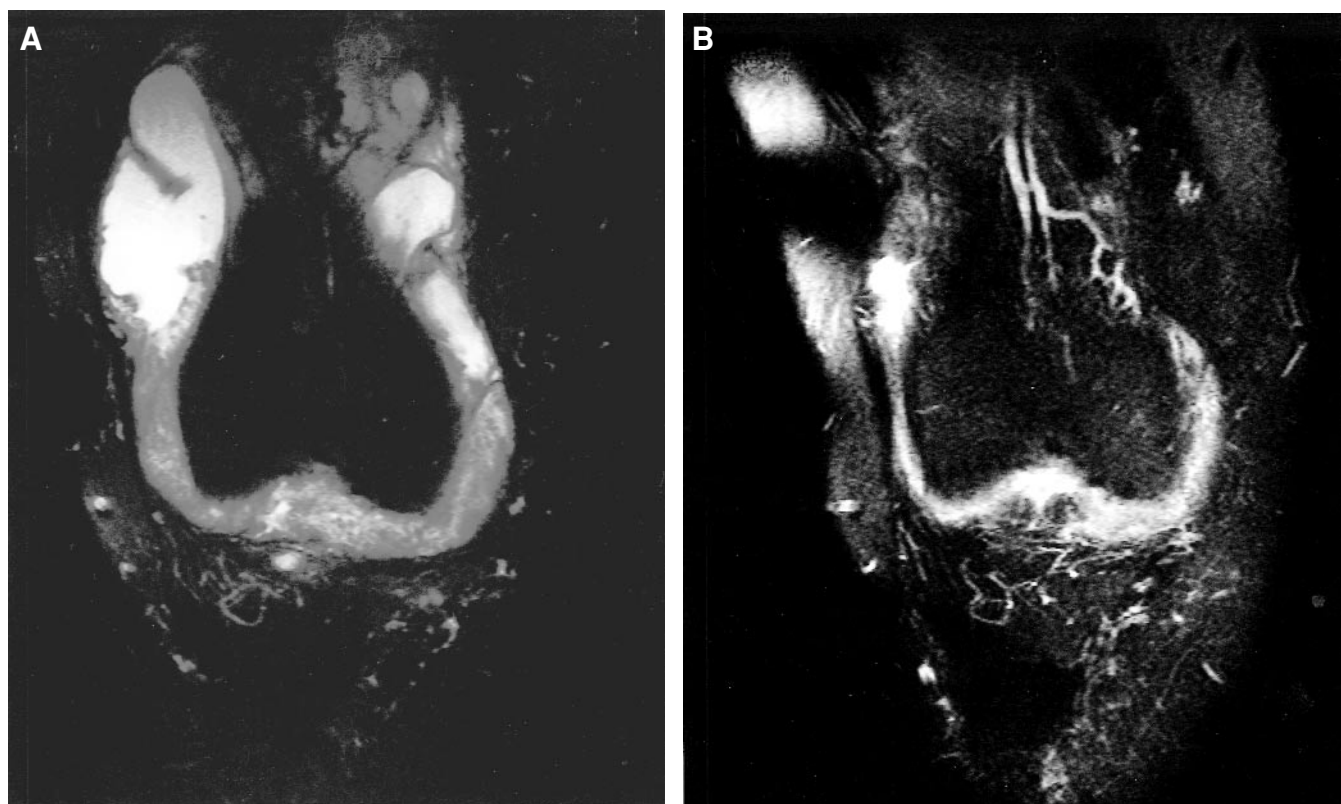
MRI of a 60-year-old woman with a 26 year history of AS and bilateral knee synovitis unresponsive to intraarticular steroids. A. Coronal T2 TSE with fat saturation (TR 4000, TE 96 ms) at the level of the trochlear groove — pretreatment baseline. This anterior image shows extensive synovial thickening along the medial, lateral, and anterior borders of the femoral condyles. A very large joint effusion fills the medial and lateral reflections and suprapatellar bursa. B. Coronal T2 TSE with fat saturation, identical location — posttreatment. Synovial thickening has dramatically improved and effusion has almost resolved.
